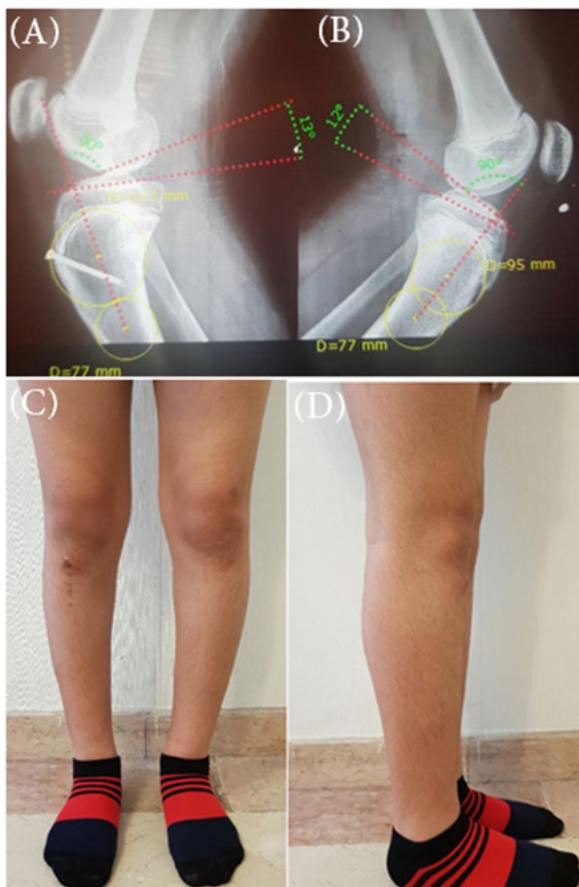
Lateral radiographs show the posterior tibial slope of the involved knee (A) and contralateral knee (B) at the final follow-up; Anteroposterior and lateral photographs of the patient's knees at the final follow-up (C & D).
